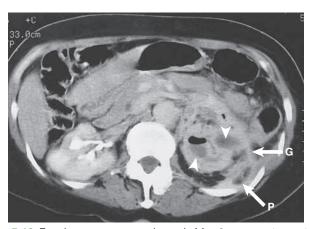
Emphysematous pyelonephritis. Contrast-enhanced CT scan shows gas (arrowheads) within an enlarged left kidney and marked enhancement of the Gerota fascia (G) and posterior perirenal space (P), indicative of inflammatory involvement.
